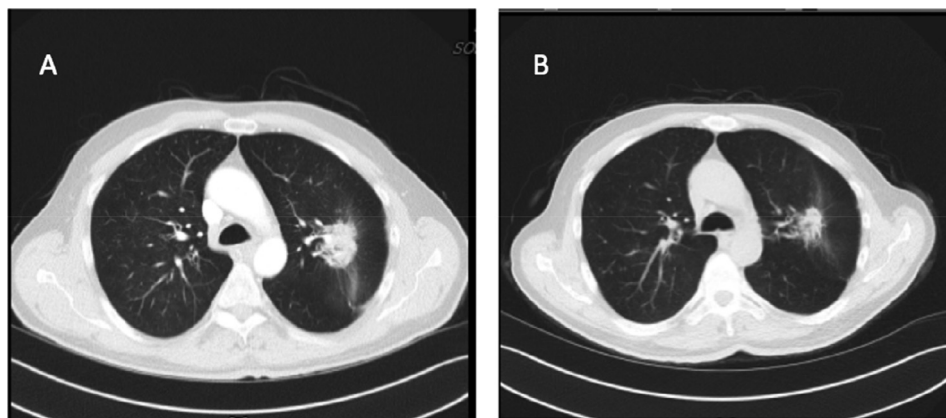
(A) Pretreatment thoracic CT on July 2017; (B) After 3 cycles of paclitaxel plus bevacizumab therapy, a prominent regression of left lung lesion (case 1).
